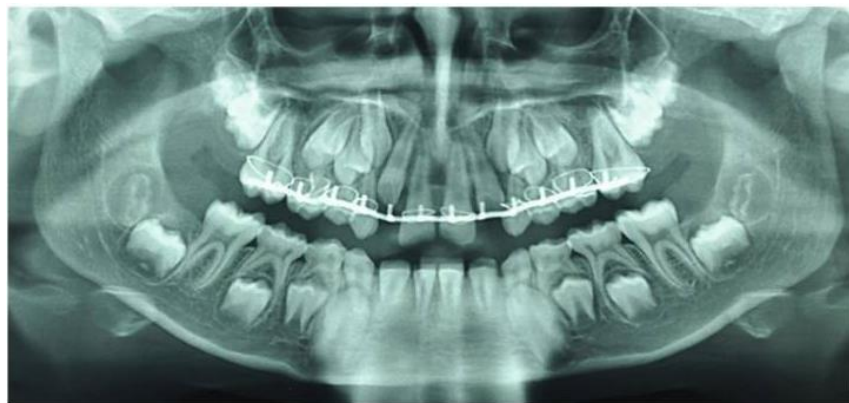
Panoramic radiograph from October 2015, prior to the removal of the Dautrey arch. Munoz-Sanchez et al., 2021
